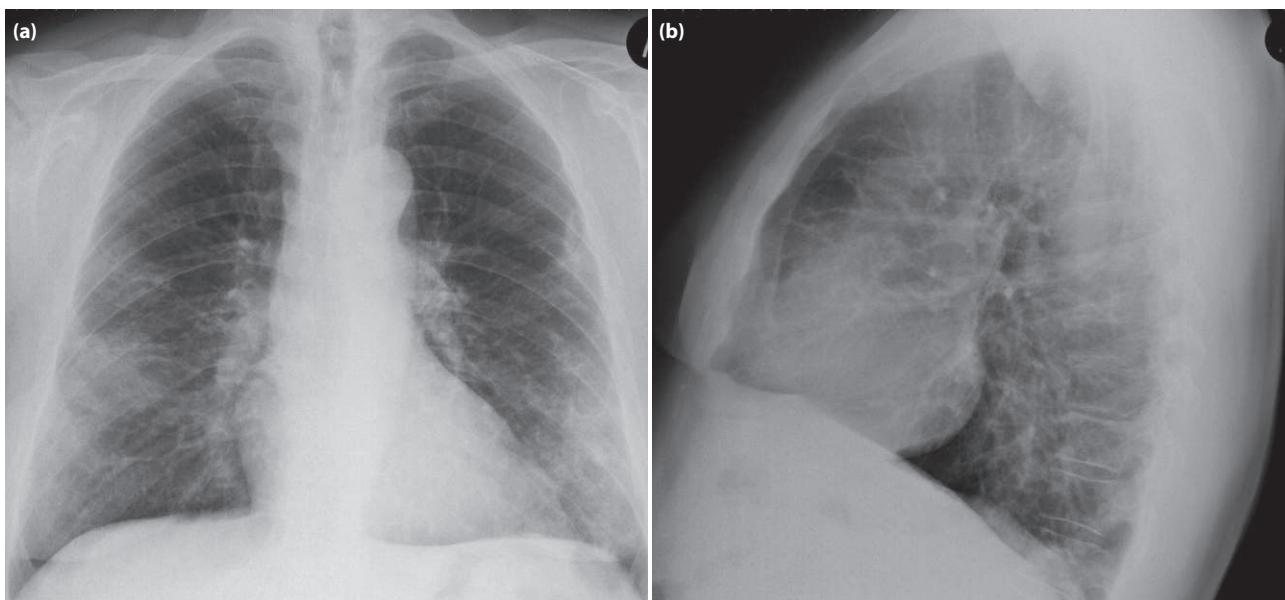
Chest X-ray face (a) and profile (b) revealed bilateral, peripheral opacities with lower zone distribution.
